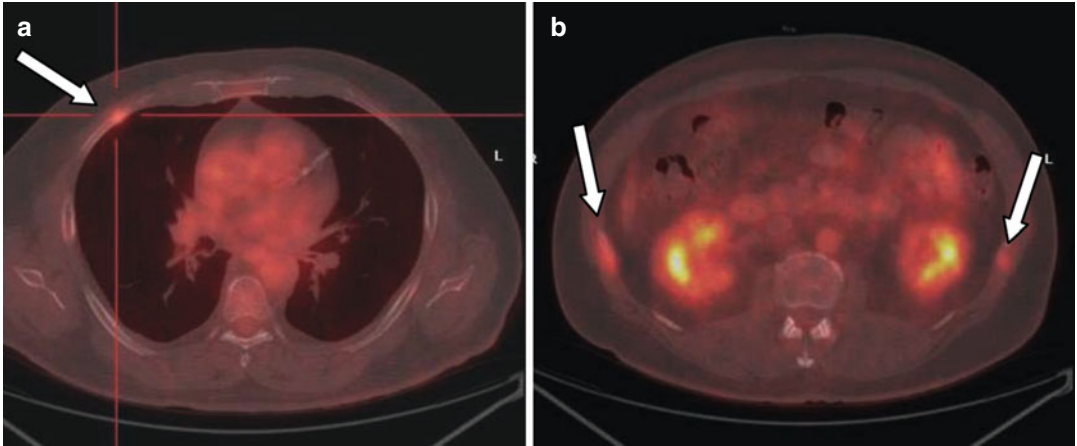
Axial PET/CT after first-line therapy (a, b) shows increased metabolic activity in the right 4th rib and 11th rib bilaterally (arrows)
